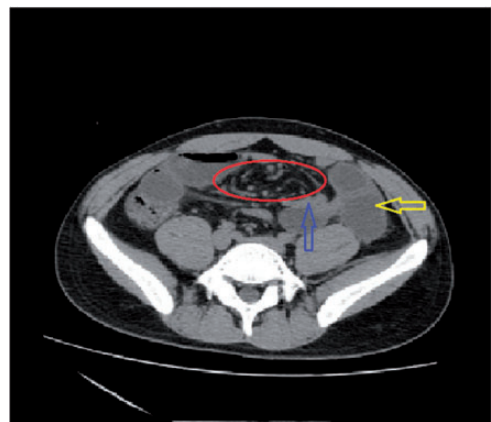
Contrast-enhanced computed tomography showing the "whirlpool sign" (red ring) with dilated intestine (yellow arrow) and collapsed intestine (green arrow).
